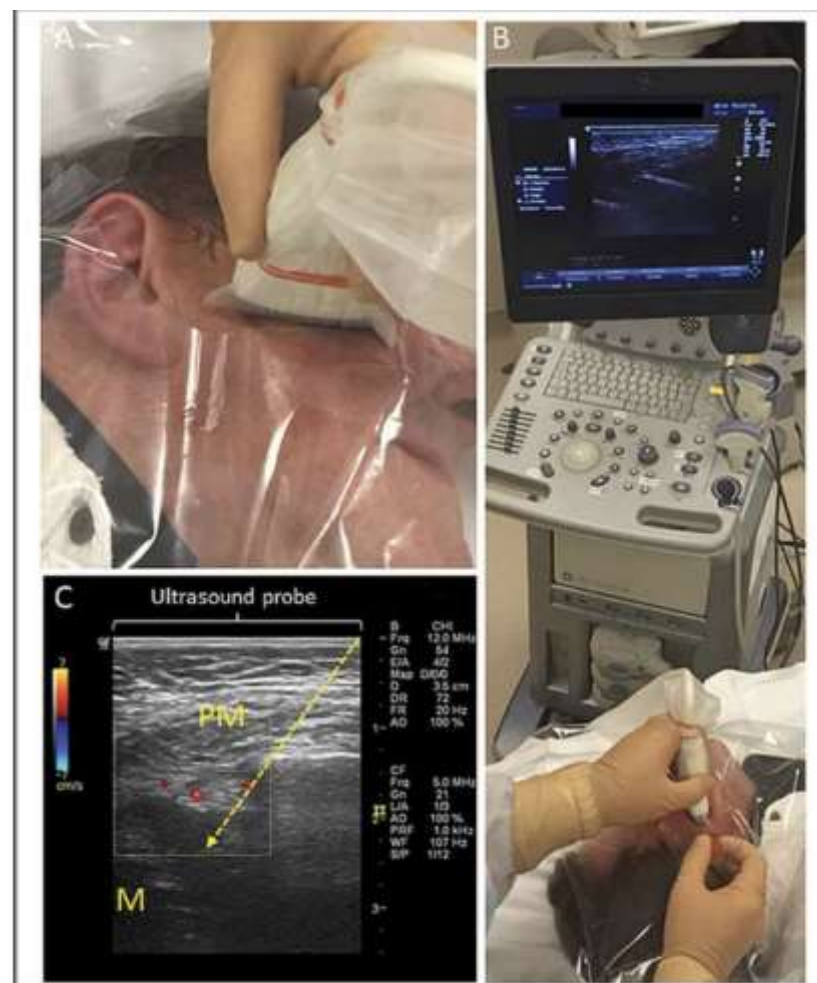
A) The ultrasound probe is positioned caudal to the zygomatic arch with cephalad angulation facilitating visualization of the target area below the zygoma. B) The needle is placed in-line with the transducer. C) The ultrasound image represents a transverse view with the top of the image displaying the ultrasound probe position. Dashed line = needle trajectory, PM = lateral pterygoid muscle, M = Maxilla. Maxillary artery detected by color flow Doppler.
